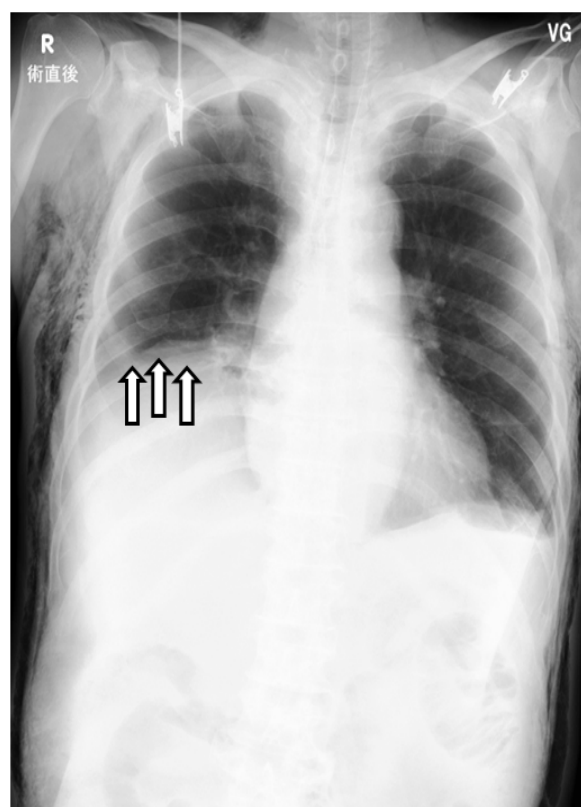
Chest radiograph immediately after surgery. Significant elevation of the right diaphragm was noted (arrow).
